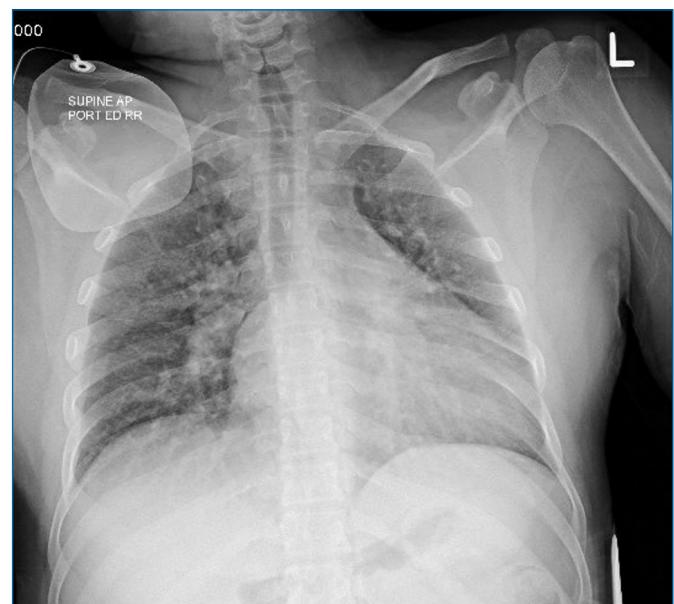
The chest Xray of the patient at admission
